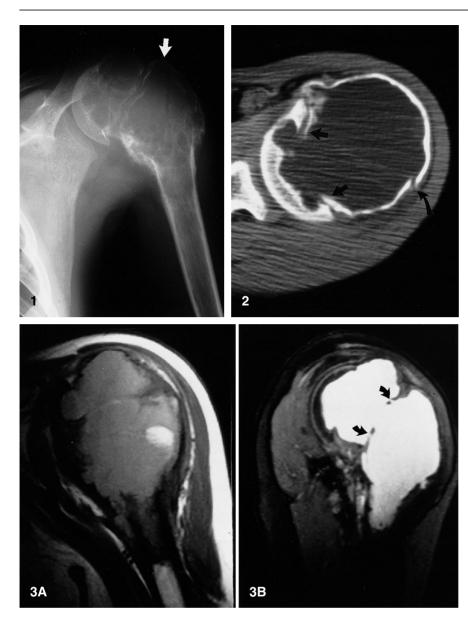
Plain radiograph of the left shoulder demonstrates a lytic, expansile lesion of the proximal humeral metaphysis, extending through the physis into the epiphysis. Note the deformity and callous formation in the medial aspect of the humerus, secondary to a healing pathological fracture. A linear lucency is seen extending vertically through the lytic lesion, representing an acute fracture. Observe the expansion of the lateral aspect of the epiphysis (*arrow*) and the medial slippage
